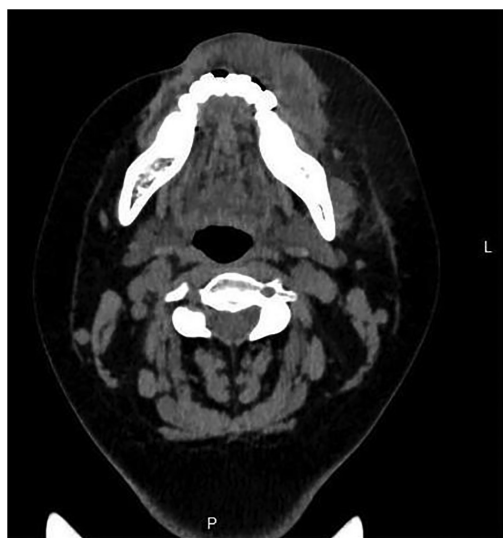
Computed tomography scan of the soft tissue swelling around the mandible before treatment. L, left; P, posterior.
